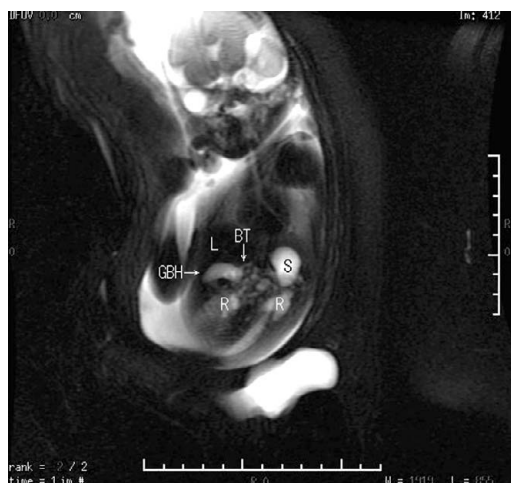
Fetal magnetic resonance imaging, coronal view, at 25 weeks of gestation shows gallbladder hydrops with its long axis perpendicular to the axis of the spine and bilateral renal pyelectasis. L = liver; BT = biliary tracts; GBH = gallbladder hydrops; S = stomach; R = renal pyelectasis.
